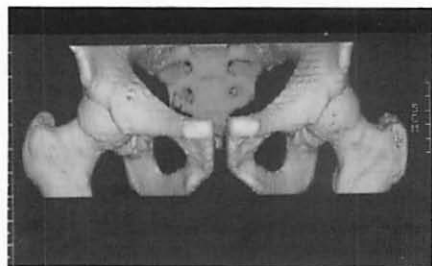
3D Rendering of a Spiral-CT 5mm/5mm reconstructed each 5mm
